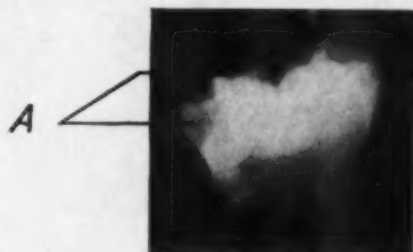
Roentgenogram of molar tooth depressed by the expanding tumor. Note enamel hypoplasia at A. (Pl. 8315.)
